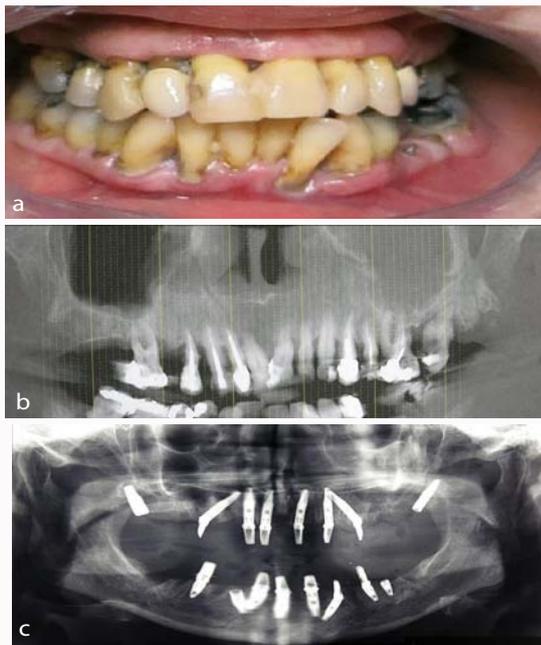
(a) Preoperative clinical photograph of a 54 years female patient before full mouth implant rehabilitation. The dentition was involved in severe periodontal disease, grade 3 mobility and failing restorations. (b) Preoperative Cone beam CT. The posterior maxillae were highly pneumatized, with residual bone height of 4 mm or less. Left sinus appeared to be obliterated. (c) Bilateral pterygoid implants were successfully inserted, together with six conventional implants in the anterior maxilla, bypassing both sinuses. The anterior implants were immediately loaded and the patient was provided with temporary full arch acrylic bridge at the end of the surgery.
